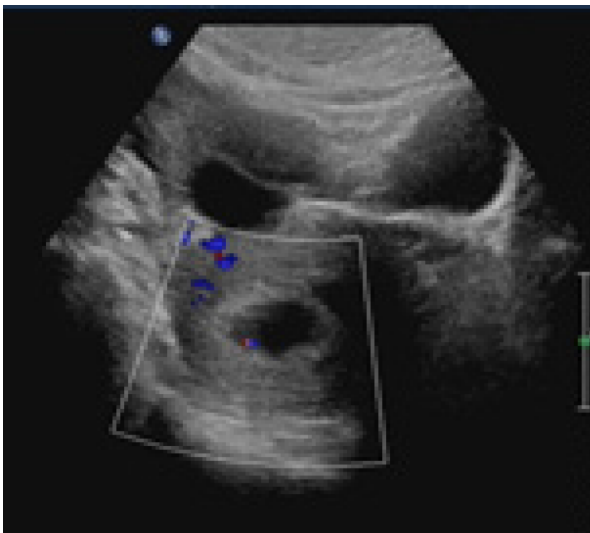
Transvaginal sonography. A: The intrauterine gestational sac was about 7 wk of pregnancy; B: The bilateral ovaries were larger than normal. The left ovary measured 8 cm × 4 cm, while the right ovarian mass measured about 11 cm × 5 cm, suggestive of an ectopic pregnancy.
